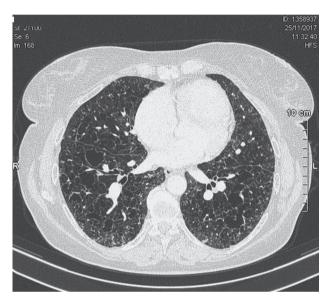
High Resolution CT (HRCT) axial image of Patient A showing multiple innumerable thin wall cysts, some bizarre shaped with nodules in the intervening lung parenchyma. Cardiac silhouette is of normal size.
